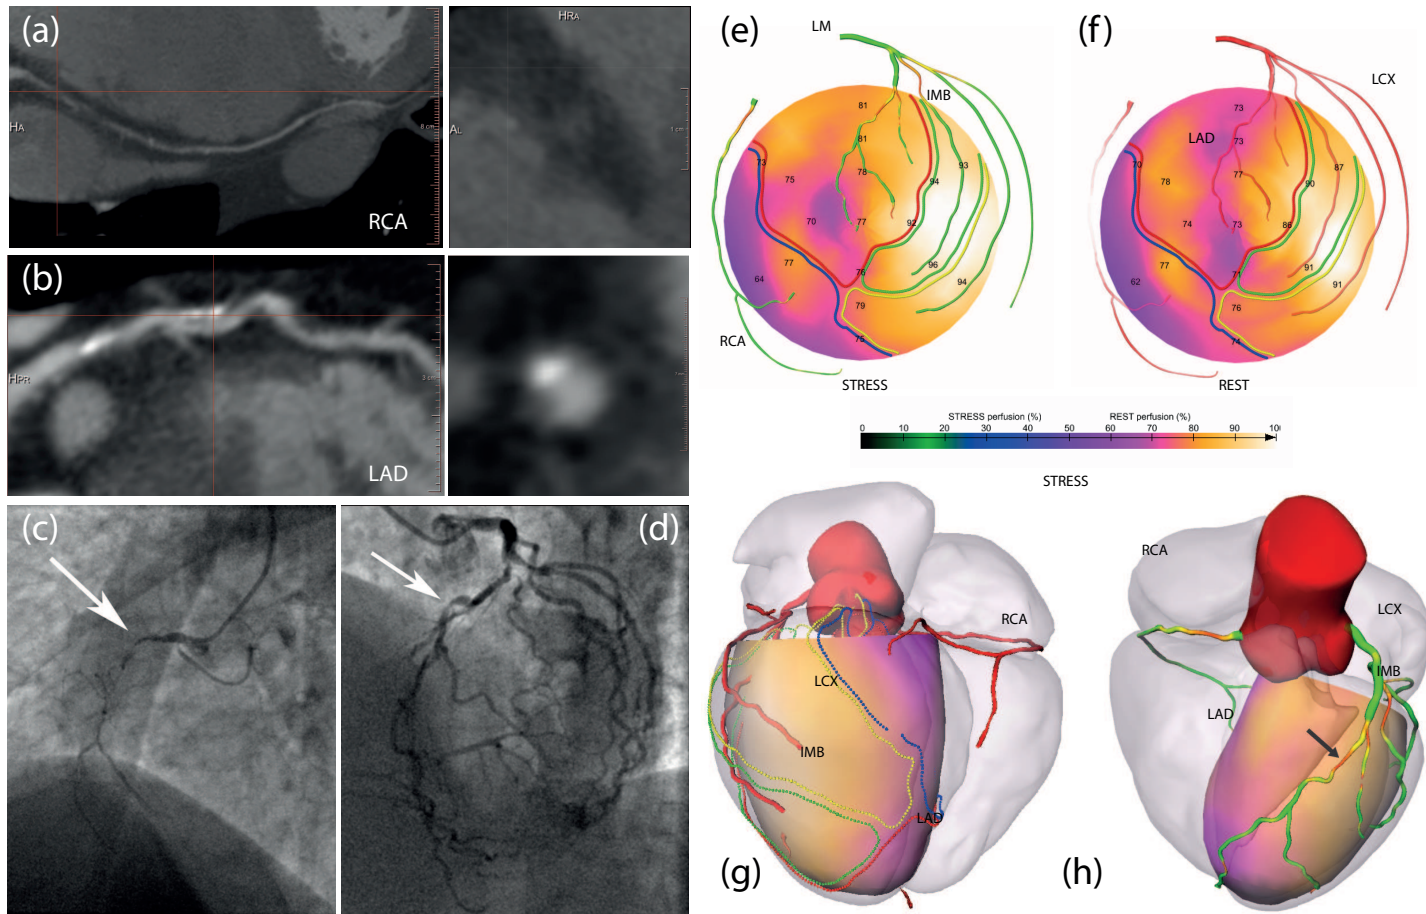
Example of patient 14 (male, 59 y.o.), who presents fixed perfusion defects in the inferior and anterior wall on SPECT-MPI and suspected triple-vessel disease on CTA. A complete occlusion was detected in the proximal RCA (a) and a moderate mixed plaque was detected in the middle LAD (b). The QCA reveals a complete occlusion in proximal RCA (c) and a 50% stenosis in the middle LAD (d). Comprehensive visualizations proposed in the SMARTVis system – (e)(f) 2D stress and rest polar maps (PMAP) fused with projection of the coronary tree extracted from CTA. On the stress PMAP (e), coronary arteries are color coded with the degree of stenosis; on the rest PMAP (f), coronary arteries are coded with the distance to the epicardium: the more transparent the artery, the further it is from the epicardium. Patient-specific perfusion territories are also projected: LAD in red, LCX in yellow, MO in green and RCA in blue. (g)(h) 3D model of the heart and coronary artery tree extracted from CTA fused with 3D stress PMAP.
